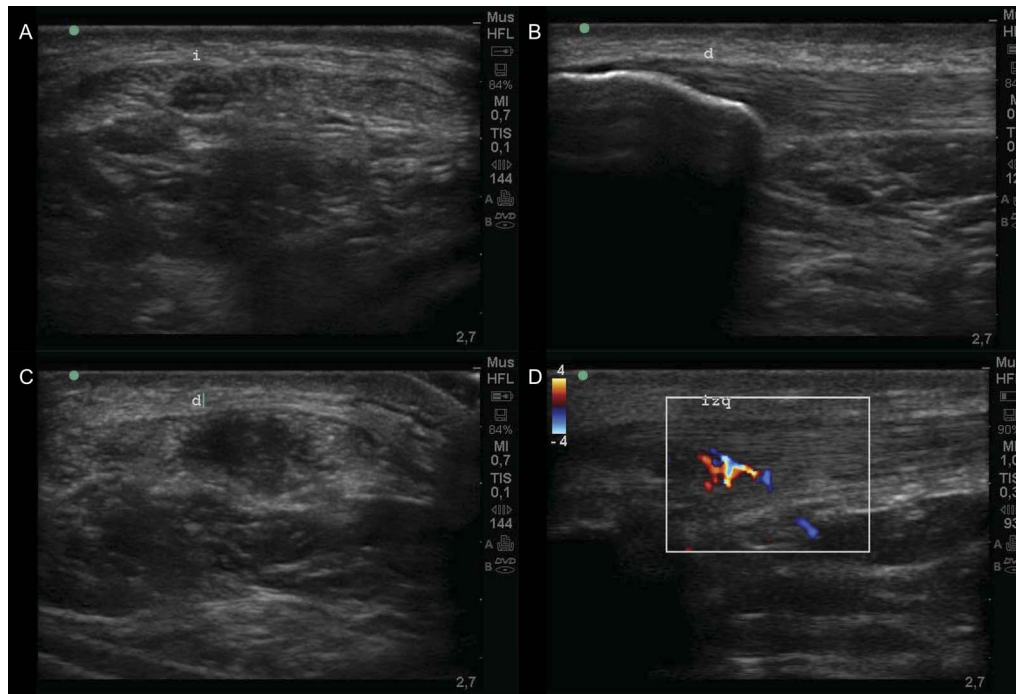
Sonographic images of tendon assessments. A, Transverse scan shows tendon with focal area of hypoechogenicity (FAH). B, Longitudinal scan shows tendon with FAH and thickening. C, Transverse scan shows tendon with FAH and thickening. D, Longitudinal view shows tendon with FAH, thickening, and neovascularization.
